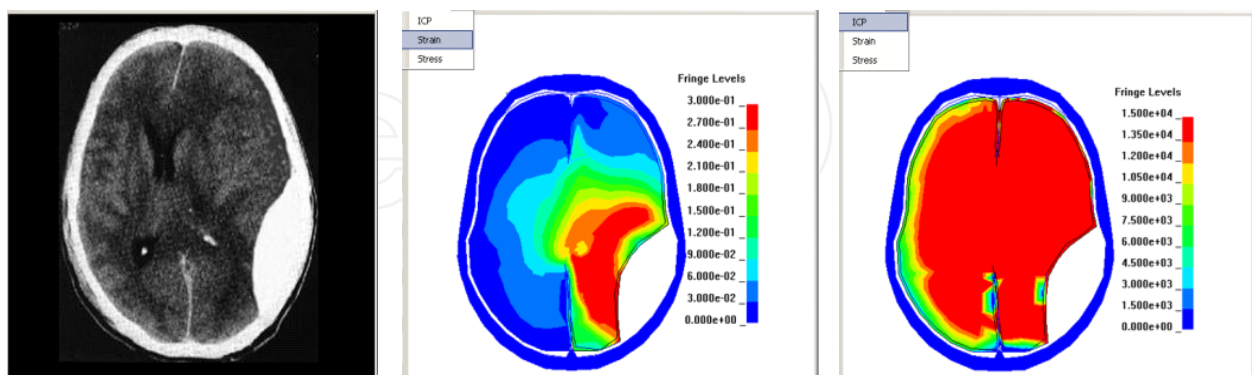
CT-verified epidural haematoma (left) analysed with NIBIE with regard to strain (middle) and ICP (right).
